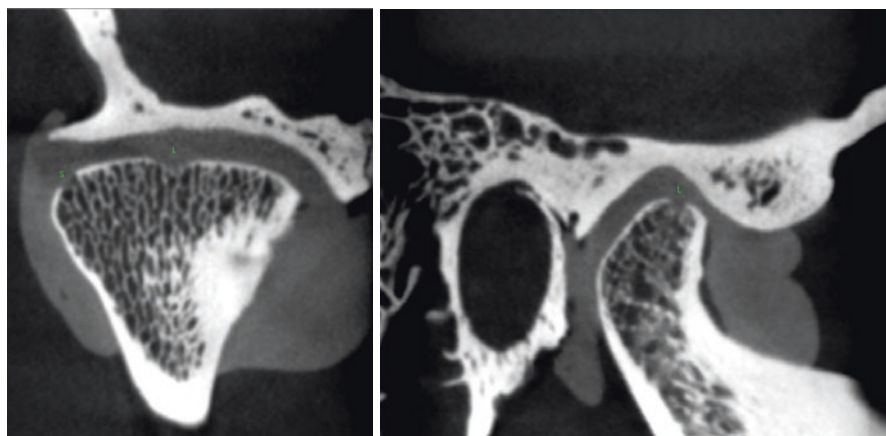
High resolution CBCT images of the TMJ
